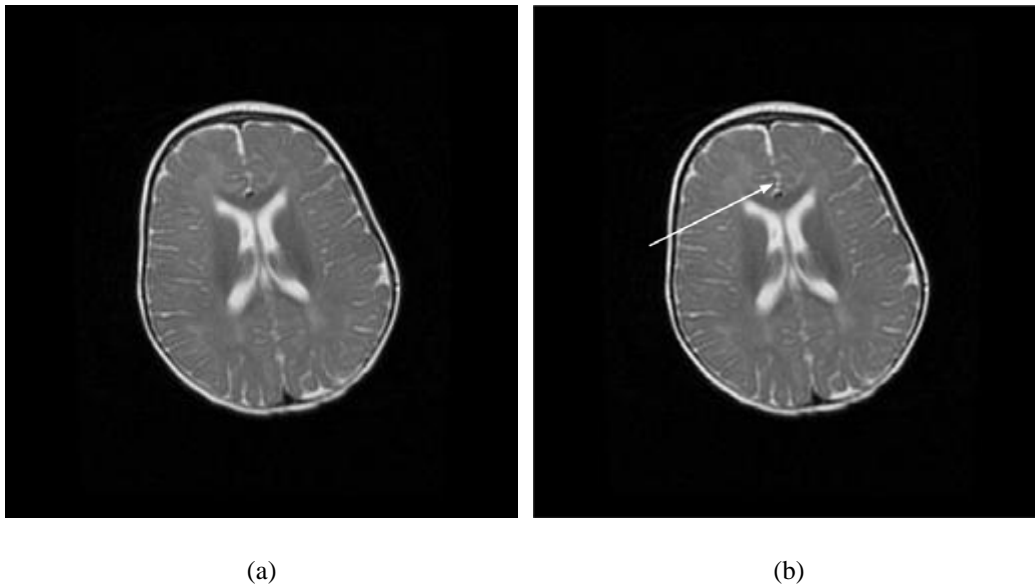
An example of image alteration. (a) a brain MR image; (b) the same MR image with an artificial lesion inserted.
